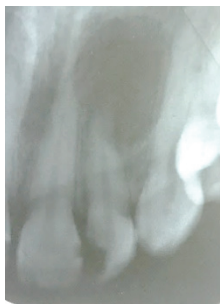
Radiographic Pre Operative
